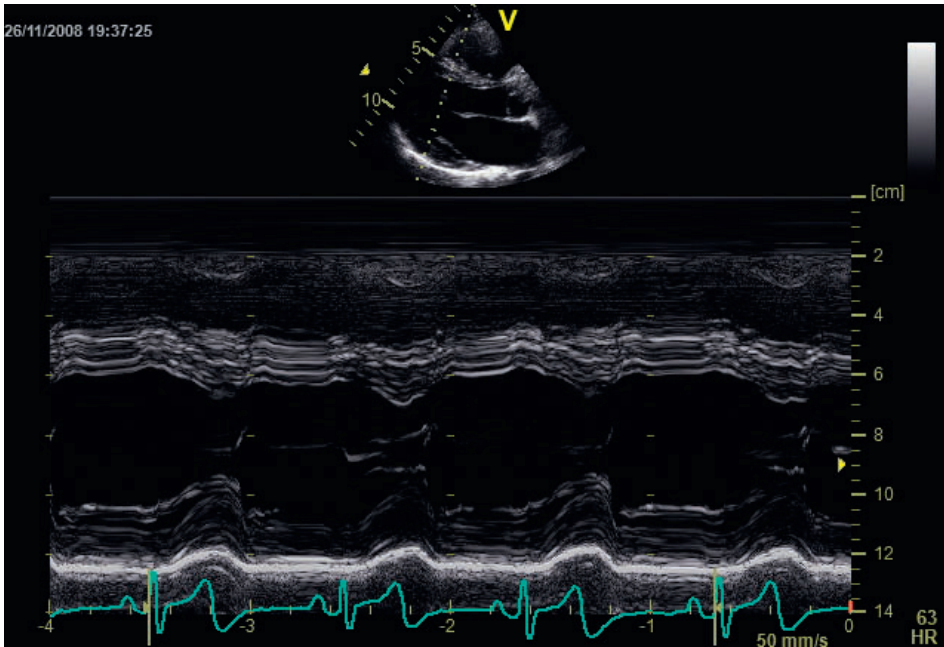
Parasternal B-mode of the left ventricle, and M-mode image of the mitral valve.
